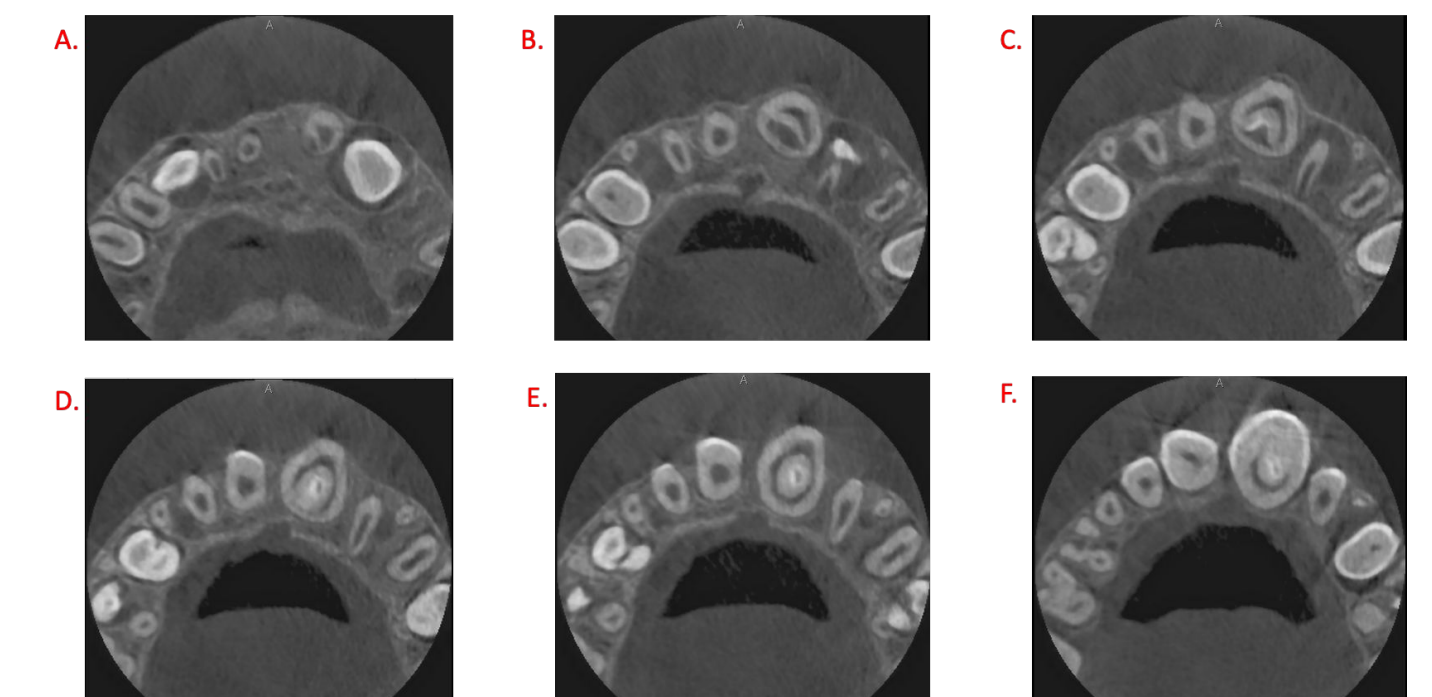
CBCT scan from root apex to occlusal surface
